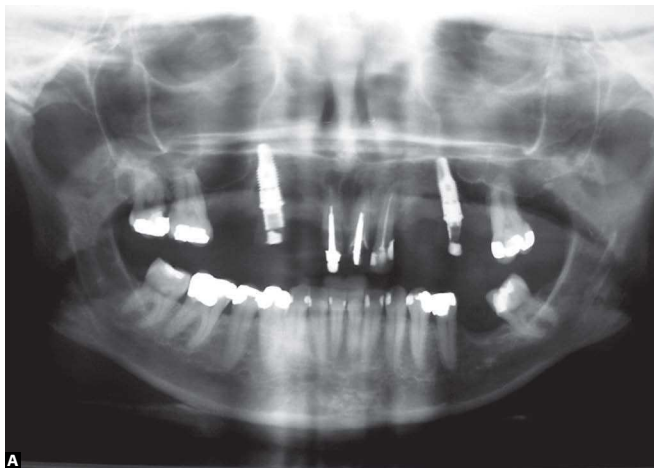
Radiograph of implants with provisional crowns installed.
